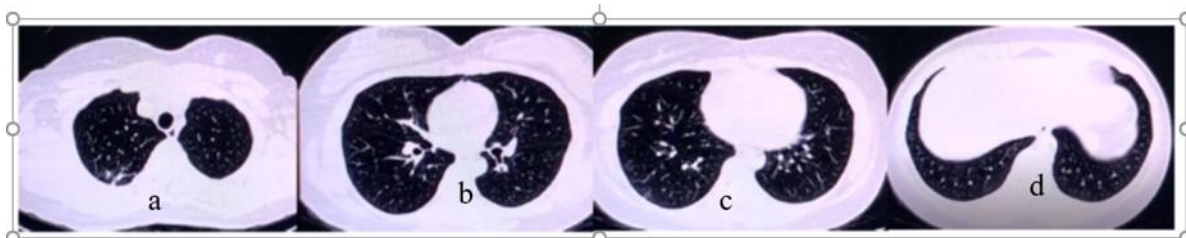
(Case 1) follow up HRCT was done 34 days after first HRCT and all of the lesions were disappear (b.c.d) except right upper posterior lung fibrosis same with old HRCT suggestive sequel TB ( a)
